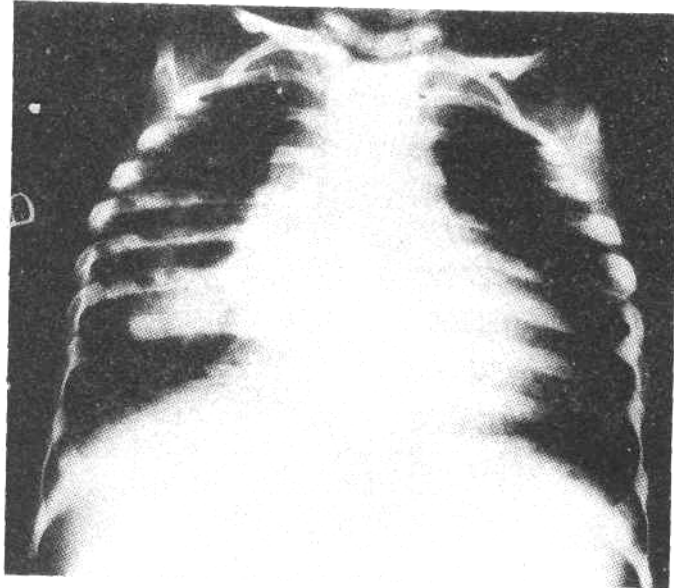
X-ray chest showing a 2.5 × 2.2 cm circular shadow in the right lower zone and nonhomogeneous nodular opacities in the right middle and lower zones.
